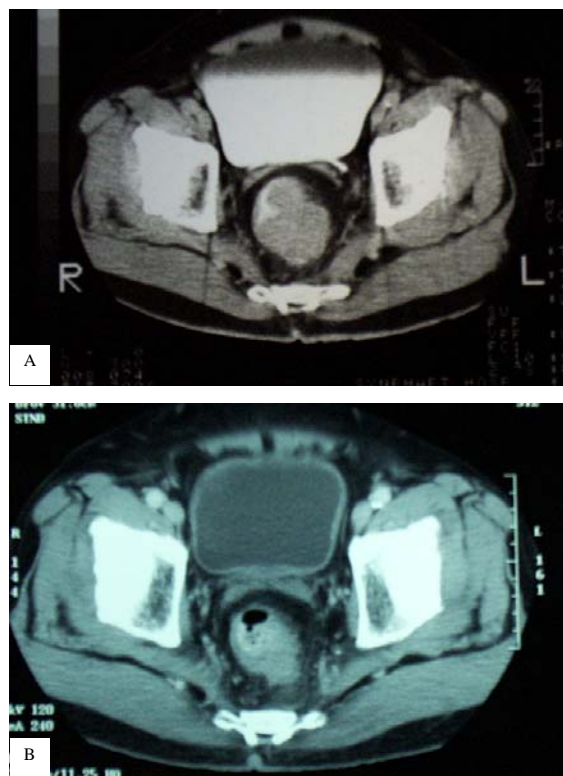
Pelvic CT scan of a patient (no.5 in Table 2) A) before and B) after preoperative combined modality therapy. The tumor downstaging was demonstrated. This patient underwent LAR and the pathological complete response was reported
